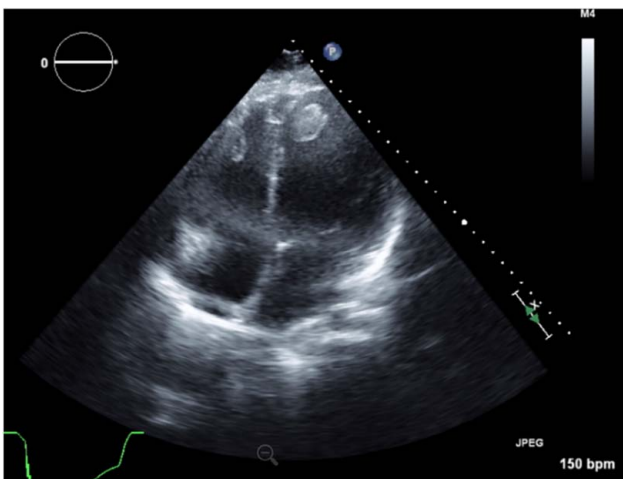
Transthoracic echocardiogram reveals severe left ventricular systolic dysfunction with global hypokinesia, an enlarged left ventricle, and a large mobile apical thrombus, indicative of dilated cardiomyopathy and associated complications.
